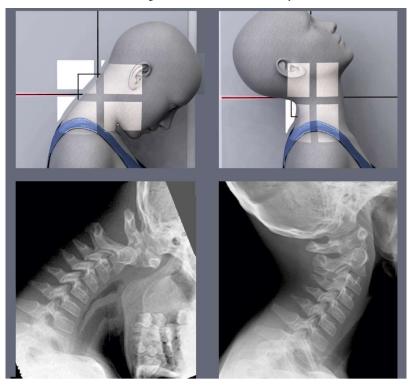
Flexion and extension radiographs of the cervical spine. Positioning and imaging are shown. These studies are normal: there is no step off in any of the four lines (see text) produced when the head is moved. (Modified from Radiopaedia.org, rID: 10338 and Radiopaedia.org, rID: 80305)
